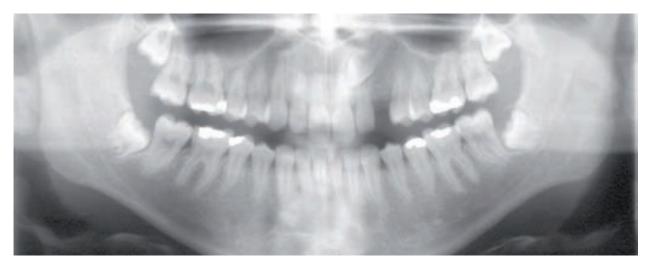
Orthopantomogram of a 15-year-old girl before starting the orthodontic treatment
